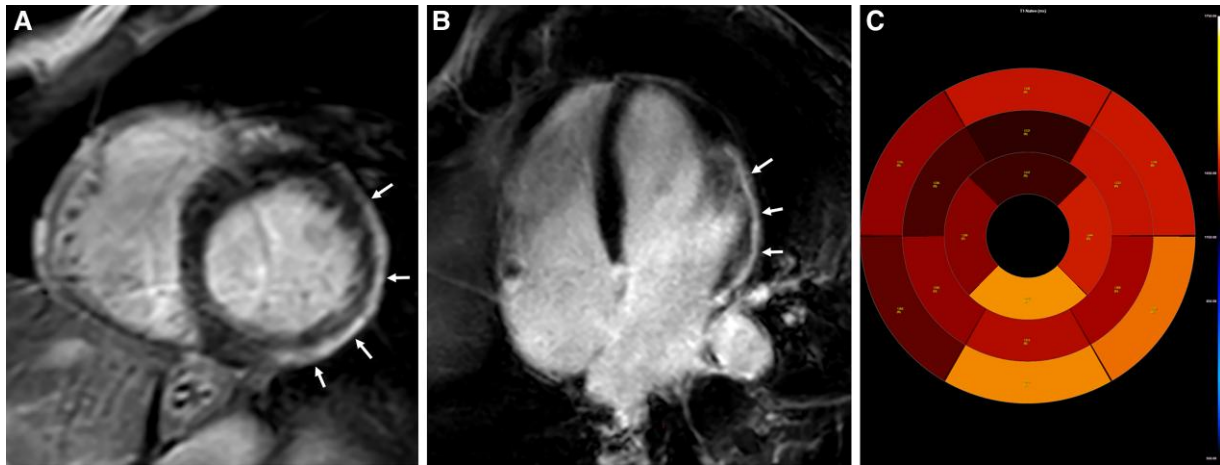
Cardiac magnetic resonance imaging demonstrating imaging features consistent with myocarditis for Patient 2. Late gadolinium enhancement (LGE) % of left ventricular mass = 19%. (A) Short-axis oblique late gadolinium enhancement demonstrating epicardial hyper-intense signal in the infero-lateral wall (white arrows). (B) Four-chamber late gadolinium enhancement demonstrating epicardial hyper-intense signal in the lateral wall (white arrows). (C) Native T₁ map demonstrating increased T₁ values in the lateral and inferior segments with values up to 1400 ms (normal values in this 3T scanner 1200 ± 50 ms).
